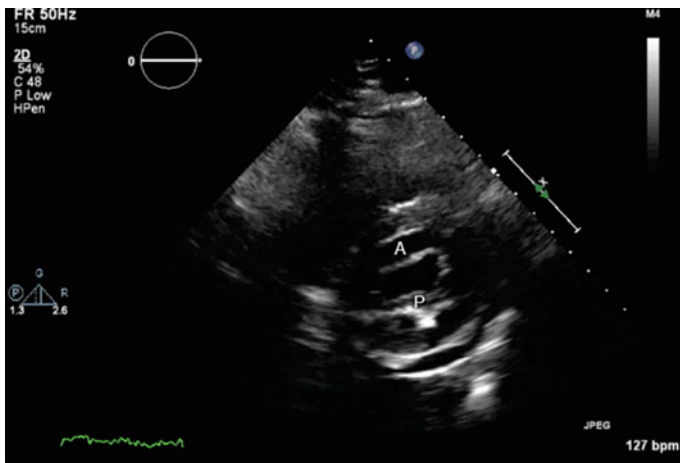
Parasternal SAX basal view of the mitral valve with the leaflets open during diastole. *A* anterior leaflet; *P* posterior leaflet
